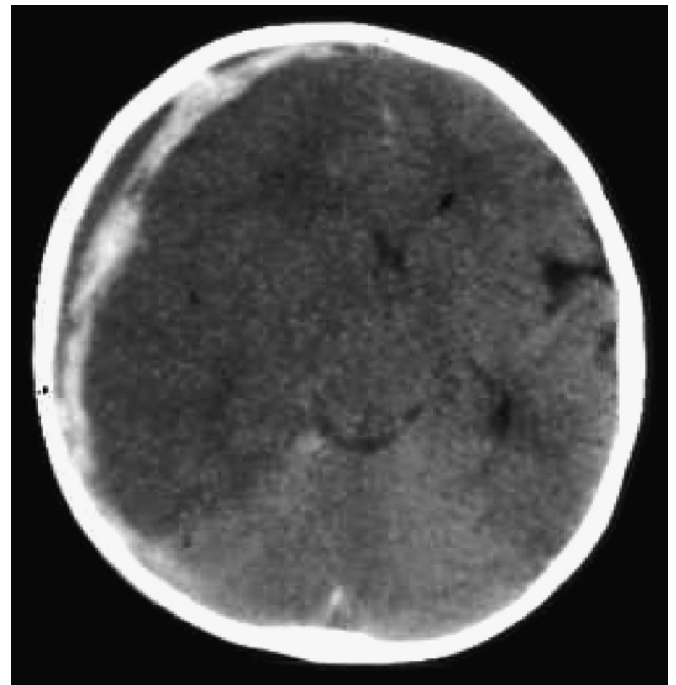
Image obtained from an 8-month-old male infant who had ALTE, right-side occipital skull fracture (not shown), a healing right-side distal radial fracture, and then had brain death. Computed tomographic image shows a right-side, mixed density extracerebral collection with right-side cerebral low density, mass effect, and leftward shift. High-density hemorrhages (or thromboses) are also present along the tentorium. There was disagreement among the forensic experts regarding hyperacute-acute SDH versus chronic SDH with rehemorrhage.
